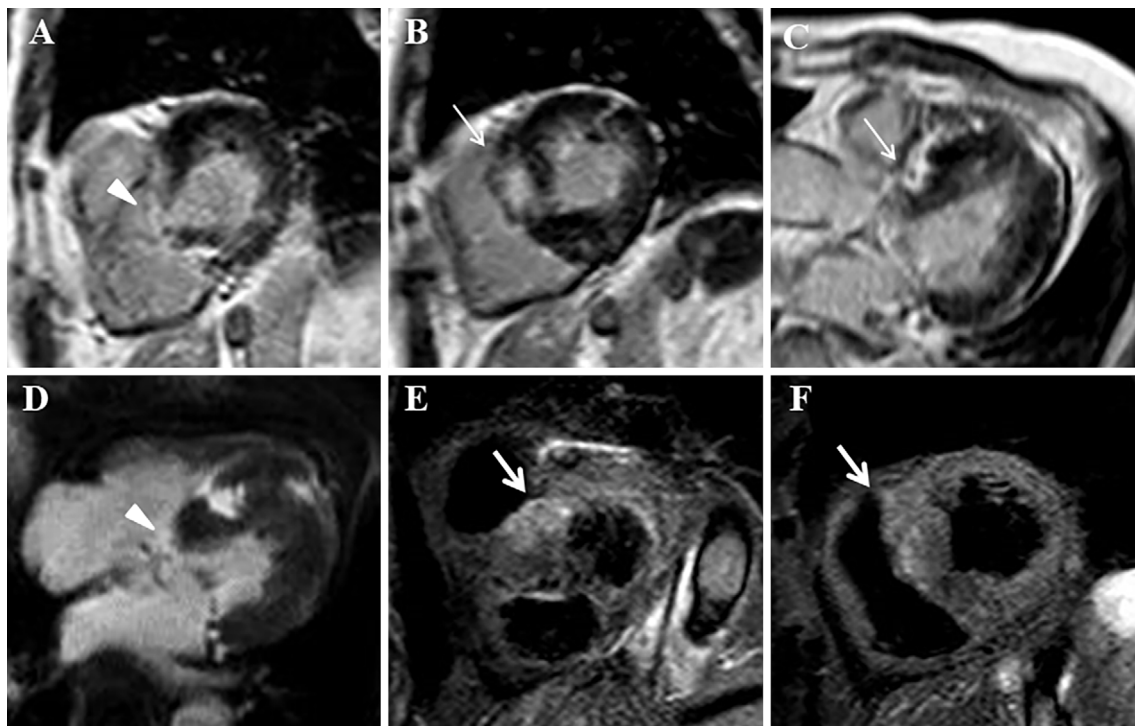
Cardiac MR images with late gadolinium enhancement (LGE) (A-D) and T2-weighted images (E, F). Basal (A, E) and basal-mid short-axis images (B, F), and long-axis images (C, D). The arrowheads indicate LGE at the upper border of the ventricular septum, the thin arrows indicate LGE at the right-ventricular side of the basal-mid septal wall, and the thick arrows indicate the high-signal-intensity area of T2 images.
